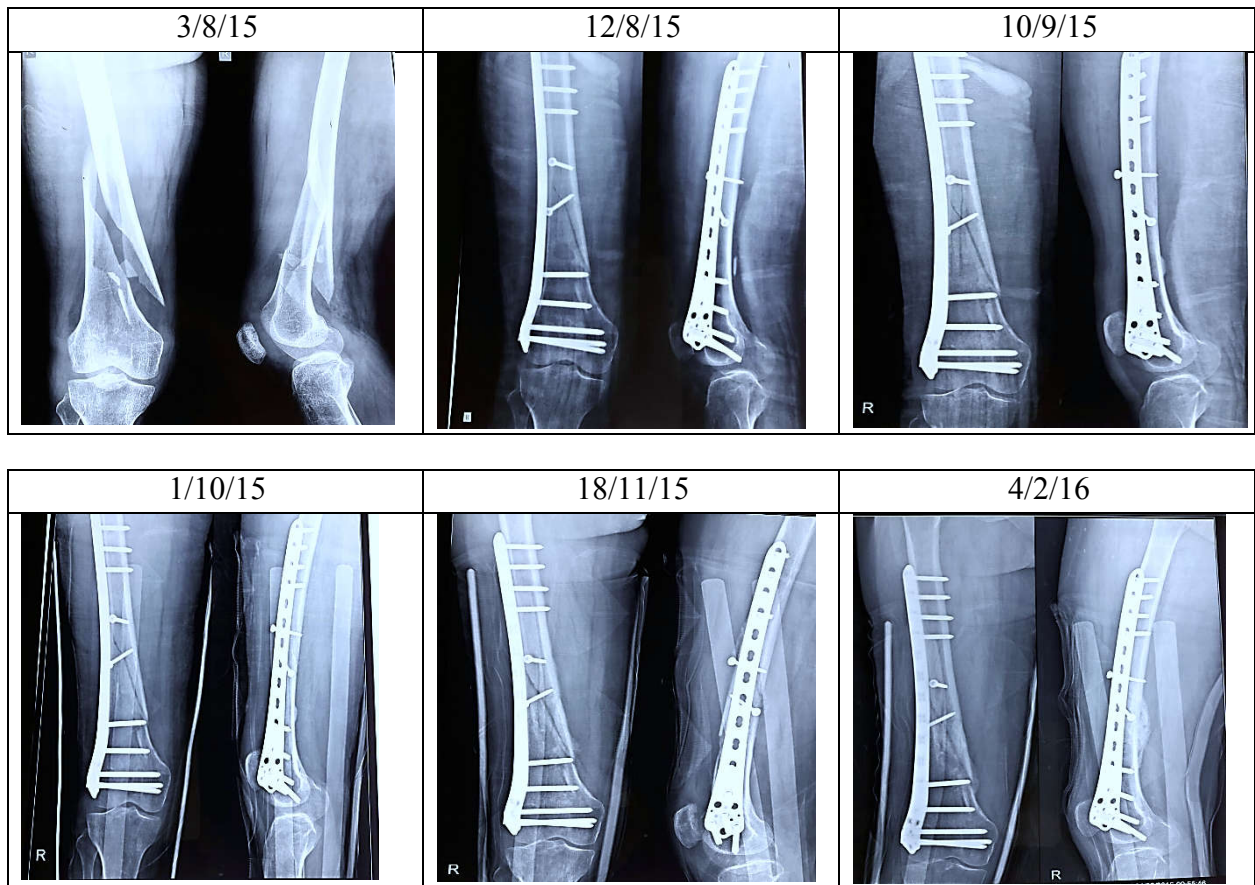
X-ray distal end of right femur antero-posterior view of case 3
